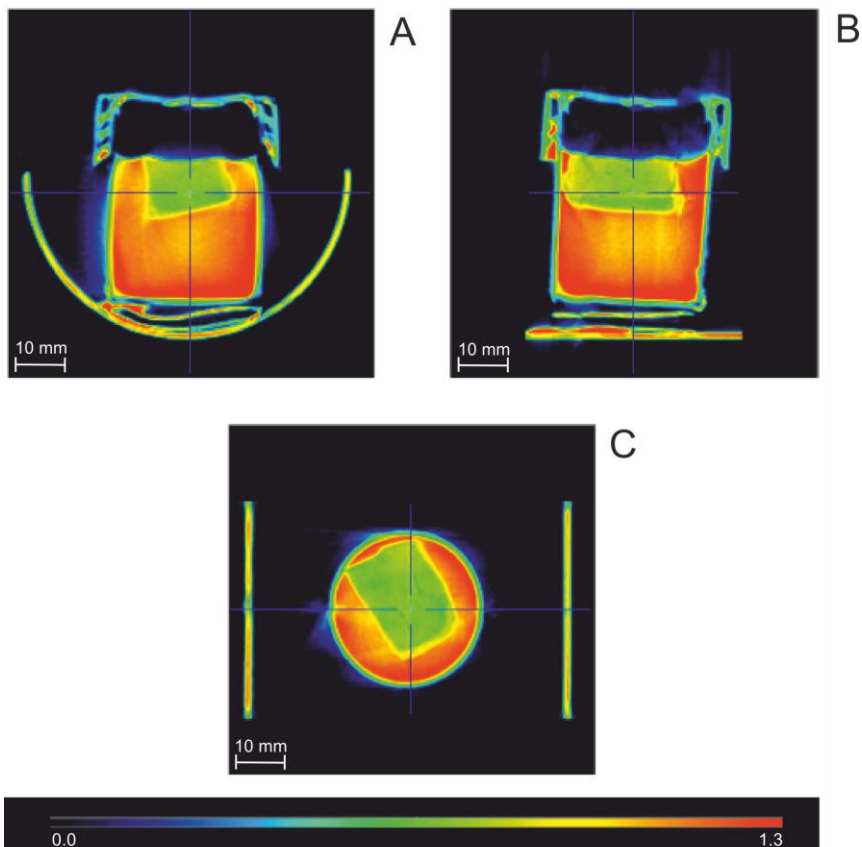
CT image of the 3 orthogonal views of an ice block in a solution of 50% v/v Me₂SO in PBS. A piece of ice of 1x1.5x1.5 cm³ was immersed in a solution of 50% v/v Me₂SO in a 20 ml vial, at -20 °C. The image uses the cold scale and the spatial resolution is 200 μm
